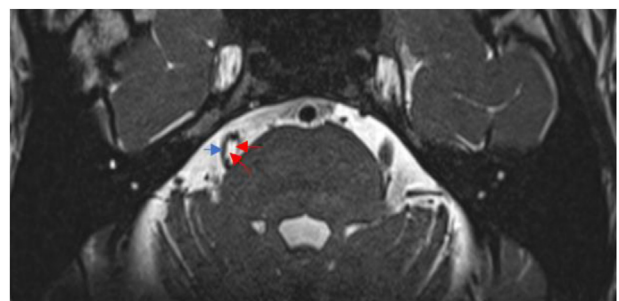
Preoperative magnetic resonance imaging fast imaging employing steady-state acquisition with phase cycling/constructive interference in steady-state sequence demonstrating the vascular loop compressing the right trigeminal nerve. The red arrows point to the superior cerebellar artery, while the blue arrow shows the trigeminal nerve bowing laterally.
